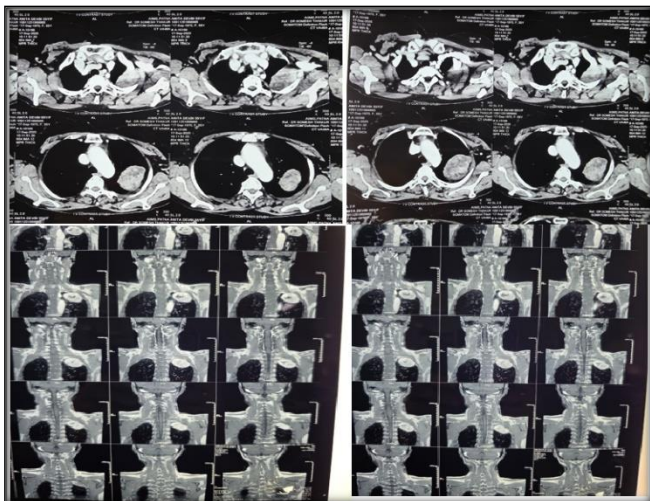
Cross-sectional imaging of the pleural mass. (A–B) Contrast-enhanced CT images showing a well-defined pleural-based heterogeneous enhancing mass along the left costal pleura adjacent to the apicoposterior segment of the left upper lobe, with central non-enhancing/necrotic areas and internal calcification; no rib erosion or extrathoracic extension is seen. (C–D) MRI images demonstrating the well-margined pleural-based soft-tissue lesion, approximately 3.8 × 5.3 × 4.0 cm.
